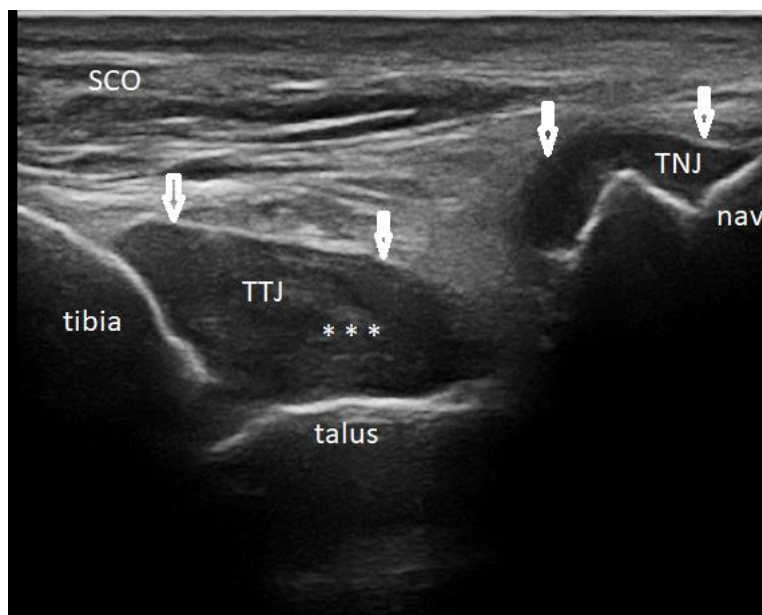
Longitudinal ultrasound image across the right ankle joint showing effusion in the Tibiotalar (TTJ) and Talonavicular (TNJ) joints (arrows), note the hyperechoic material inside the effusion in the tibiotalar (asterisks) and the Subcutaneous Oedema (SCO).
